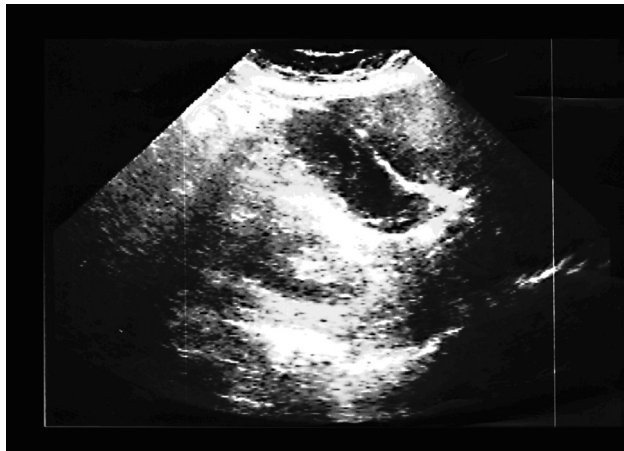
Ultrasound examination outlines a polypoid mass within the gallbladder.
